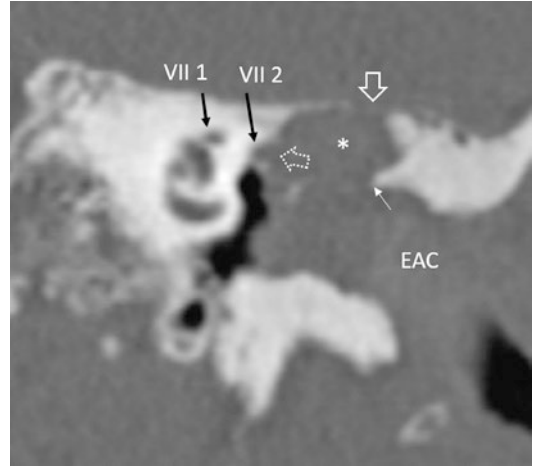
Left coronal CT image, showing a huge cholesteatoma in the attic (asterisk), with lyses of the tegmen (empty arrow), lyses of the facial nerve canal (tympanic portion, dotted empty arrow), and lyses of the scutum (thin arrow). *EAC* external auditory canal
